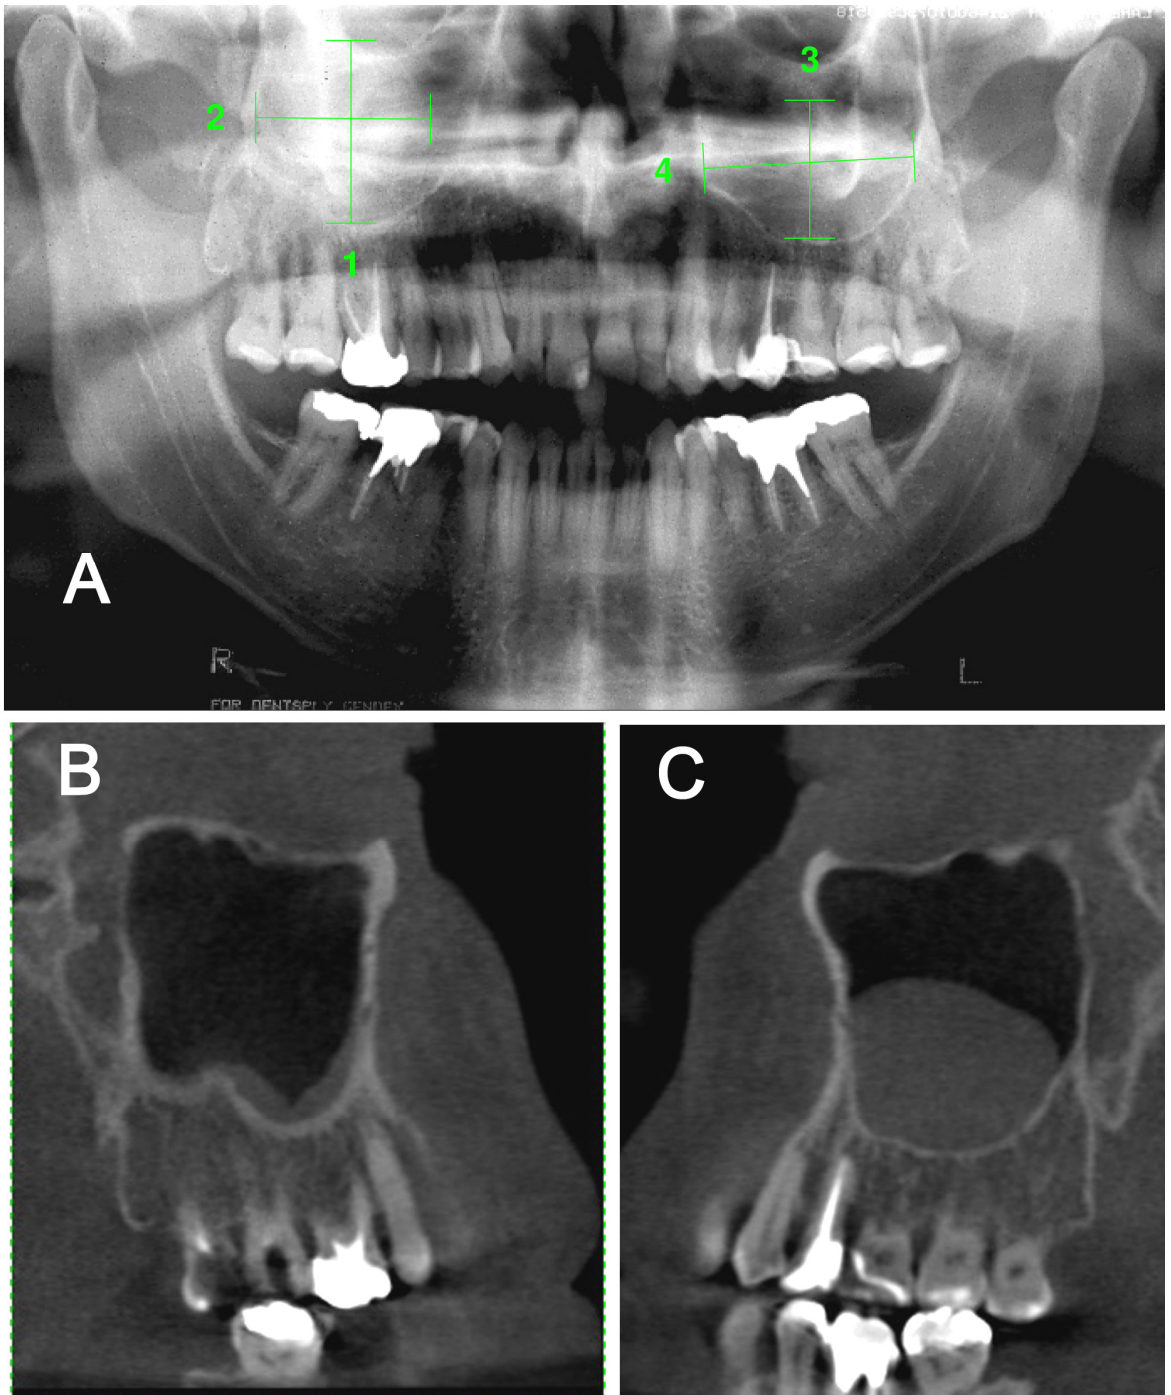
Panoramic radiography for control with bilateral MRCMS (A), sagittal CBCT reconstruction, from same patient, with absence of MRCMS in the right side (B) and presence of MRCMS in the left side (C).
